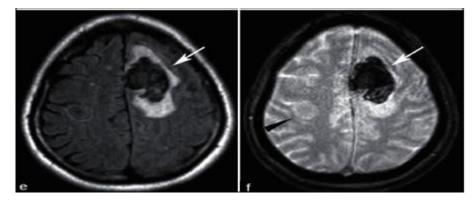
44 year-old found down. (a) NECT shows left frontal hemorrhage (arrow) with additional hyperdense lesions (arrowheads). (b) CECT shows enhancement, better delineating some of the masses (arrowheads). T1-weighted MRI without (c) and with (d) contrast shows multiple enhancing lesions. FLAIR (e) shows vasogenic edema surrounding the hemorrhage (arrow), but little edema associated with other lesions. T2* sequence (f) redemonstrates left frontal hemorrhage (arrow) but no blood within with the other lesions (arrowhead). ⁽²⁰⁾
